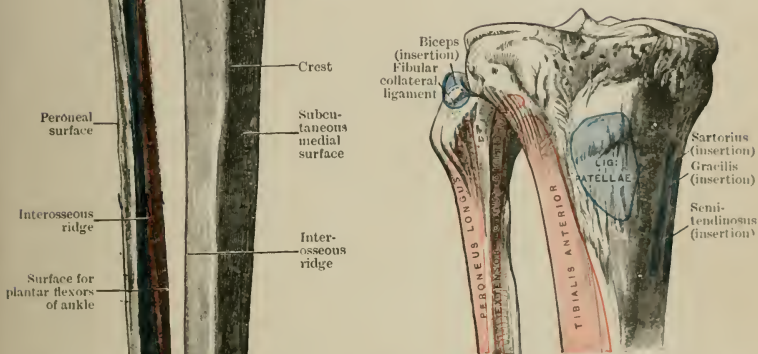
FRONT ASPECT OF THE PROXIMAL PORTIONS OF THE BONES OF THE RIGHT LEG WITH THEIR MUSCLE ATTACHMENTS.
